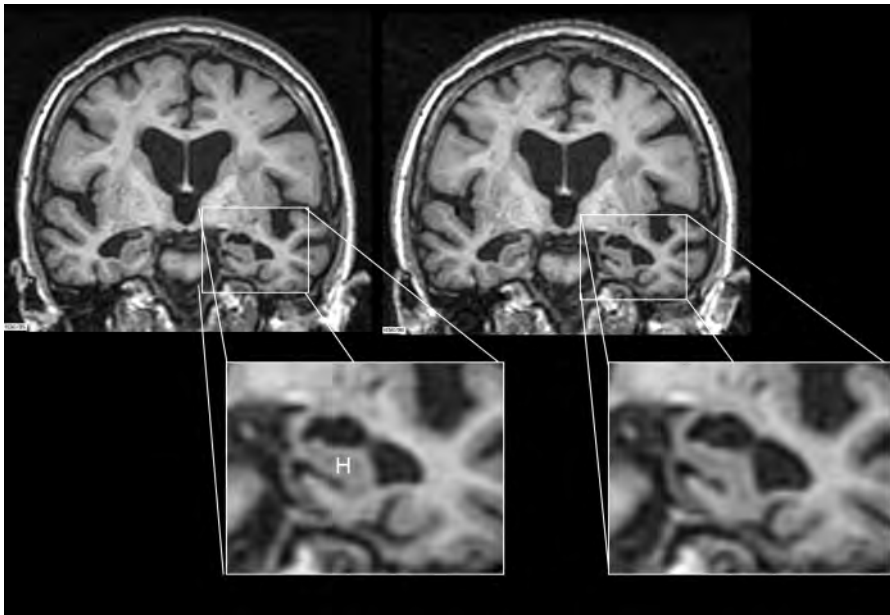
Hippocampal atrophy. Two coronal T1-weighted MRI scans of a patient with probable AD – baseline on the left; follow-up one year later registered to baseline. The inset shows a magnified view of the left hippocampus (H) with progressive atrophy over the year.
